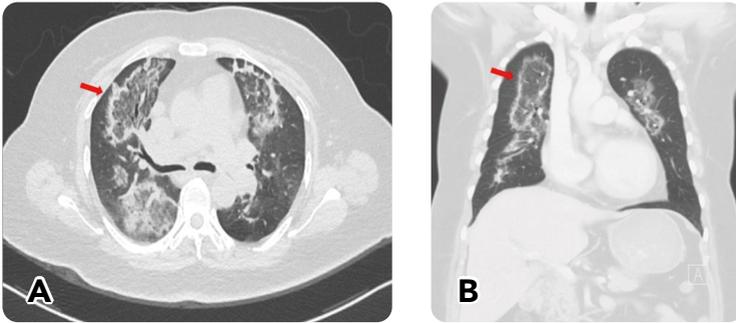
Chest CT revealed multiple GGOs with peripheral consolidations.
